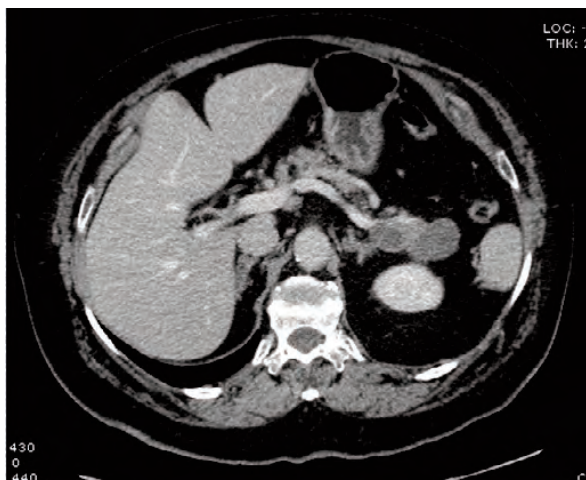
CT scan in portal phase shows the presence of an irregular lobular mass, 6 cm in diameter, located in the tail of the pancreas.
